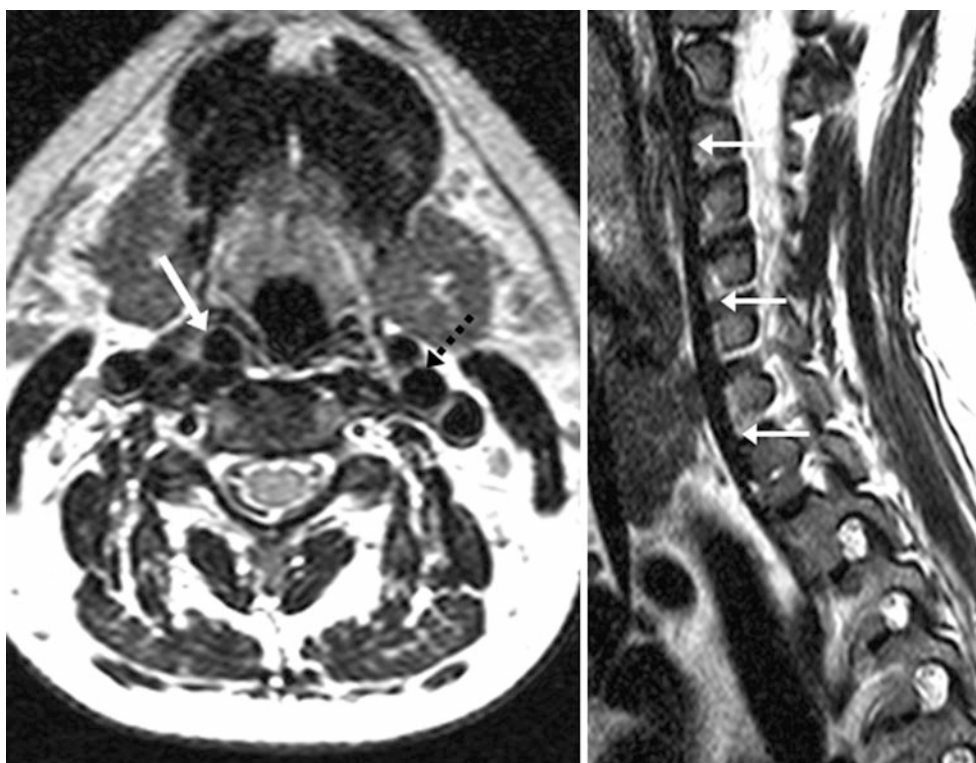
43-year-old with a unilateral right retropharyngeal internal carotid artery (ICA) (arrows), just posterior to the pharyngeal mucosa on axial (left) and sagittal (right) T2WIs from a cervical MRI. Note the typical location of the left ICA (dotted arrow)
